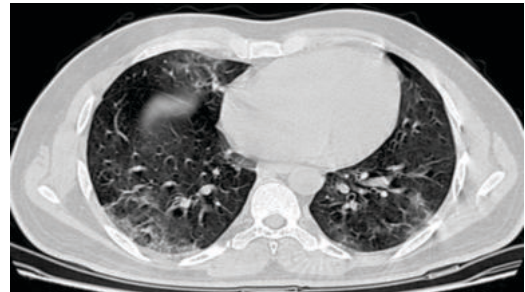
Axial HRCT Thorax Image of 41 year old Male patient with CRP value of 27 and CT severity score 6 .GGOs in subpleural and peripheral regions.(arrow)(WL:-450, WW :1500)
